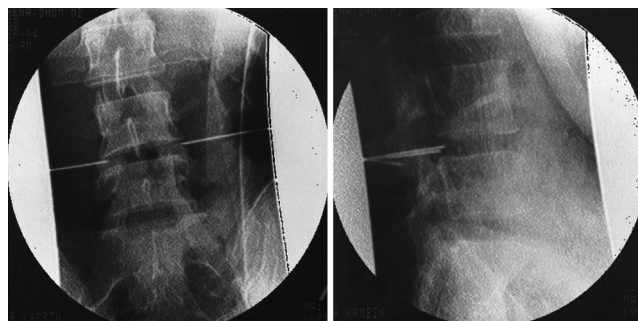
Proper positioning of the guide wire at the onset of the procedure is a prerequisite for successful decompression of the lateral recess. *Left:* Intraoperative x-ray film showing proper positioning of the guide wire in the foramen at the midpedicular line in anteroposterior projection. *Right:* Intraoperative x-ray film, lateral view, of the needle position.
